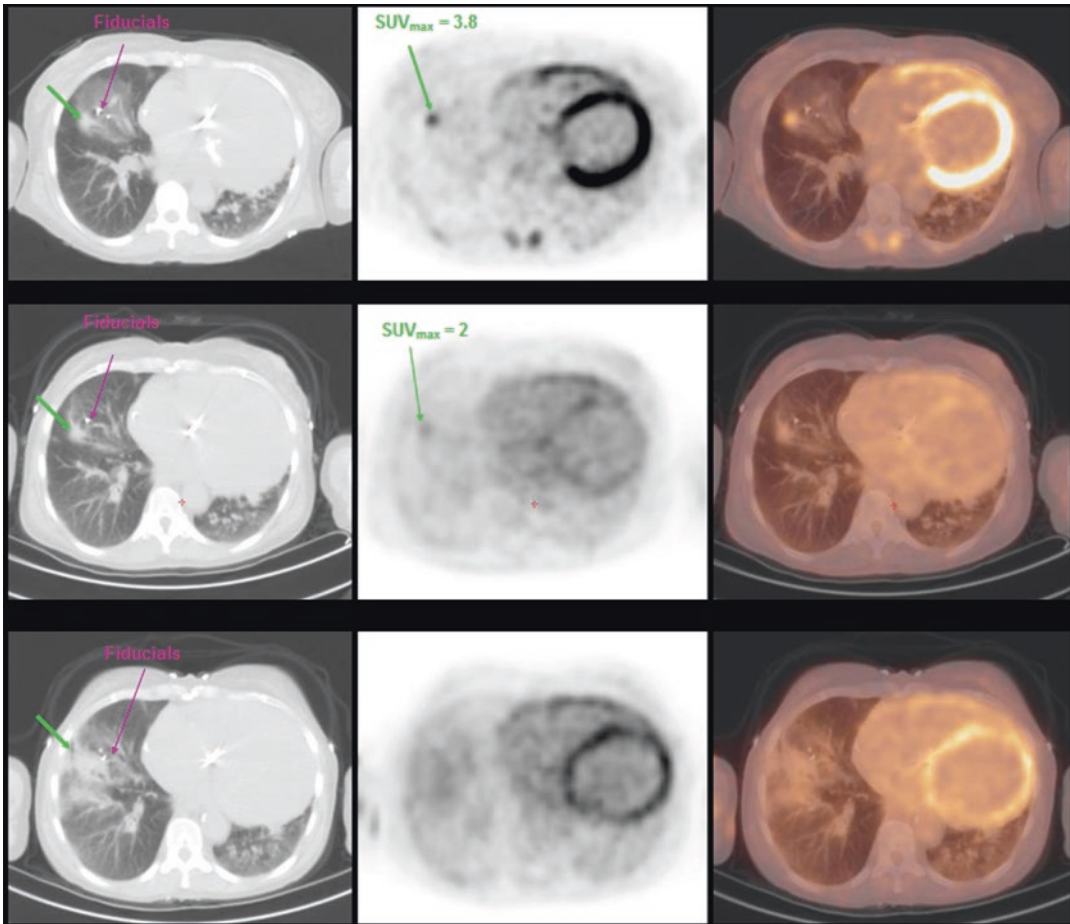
Solitary pulmonary nodule. (*Top row*) PET/CT images of a patient with a solitary pulmonary nodule in the right upper lobe with fiducials in place. (*Middle row*) 1 month after radiation with decreased metabolic
